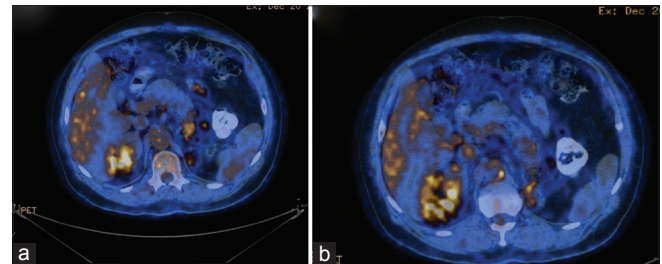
(a and b) Positron emission tomography-computed tomography scan showing right adrenal soft tissue lesion standardized uptake value (SUV - 4.6) and multiple nodules along the body and tail of the pancreas (SUV - 3.2)
